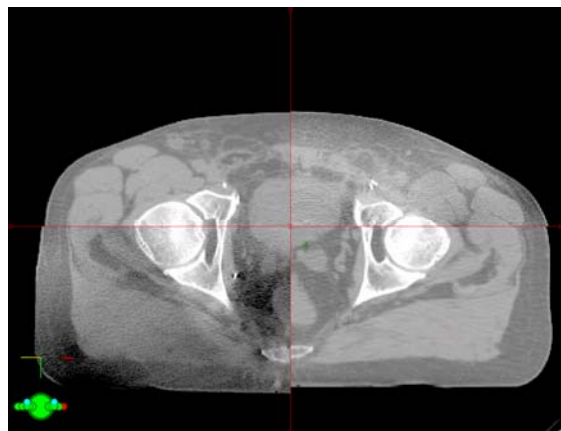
Image registration of planned CT (GE high speed 16) and Varian CBCT - prostate (CBCT - top right, bottom left)
